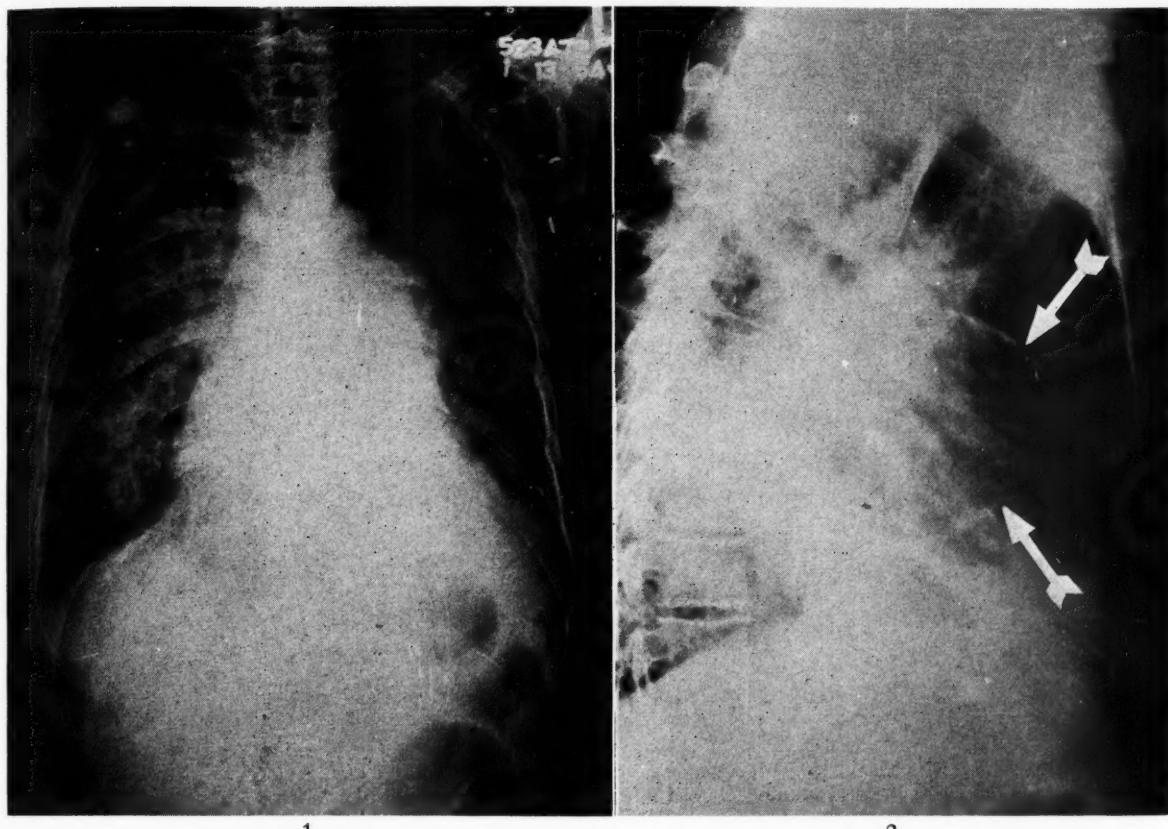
Postero-anterior roentgenogram of the chest demonstrating cardiac enlargement with a prominent, convex pulmonary artery segment. The bilateral pulmonary densities represent inflammatory and congestive changes.
